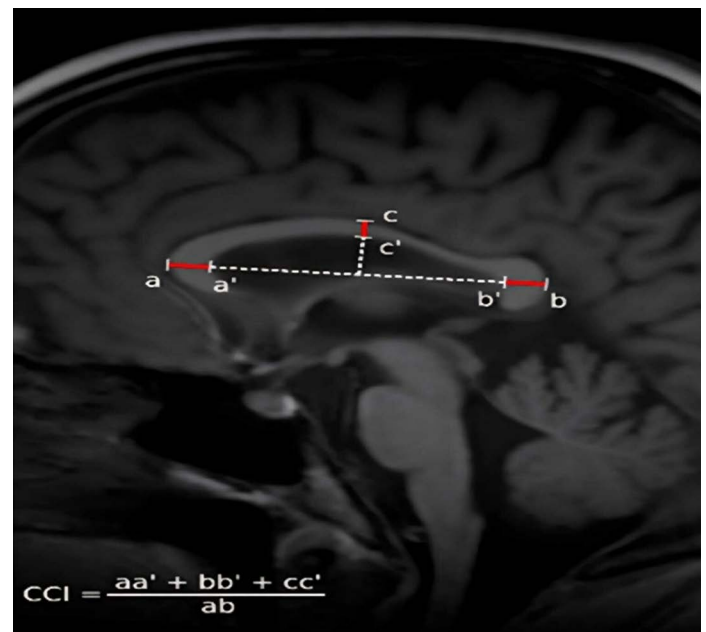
The corpus callosum index (CCI) was measured from midsagittal T1 weighted MRI images and calculated using the ratio of anteroposterior length to segmental heights according to the formula $(aa'/ab + bb'/ab + cc'/ab)$.
